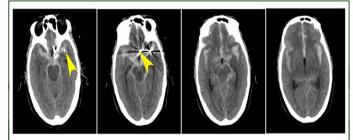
CT scan of a 63-year-old man on the day of second onset of subarachnoid hemorrhage. The yellow arrow heads indicates the coil used in the operation for the first subarachnoid hemorrhage.
